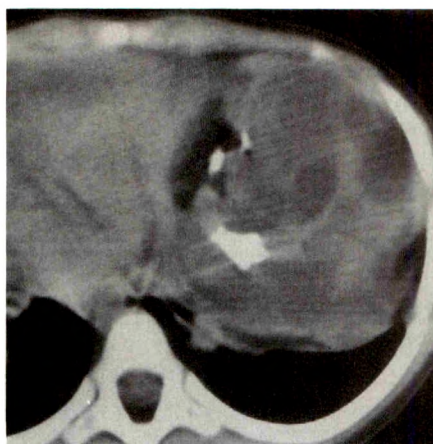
Benign mature teratoma. CT scan shows large mass containing fat, multiple cysts, and calcification. Heart is displaced to the right. Mass arose from left lobe of thymus and contained embryonic teeth.
